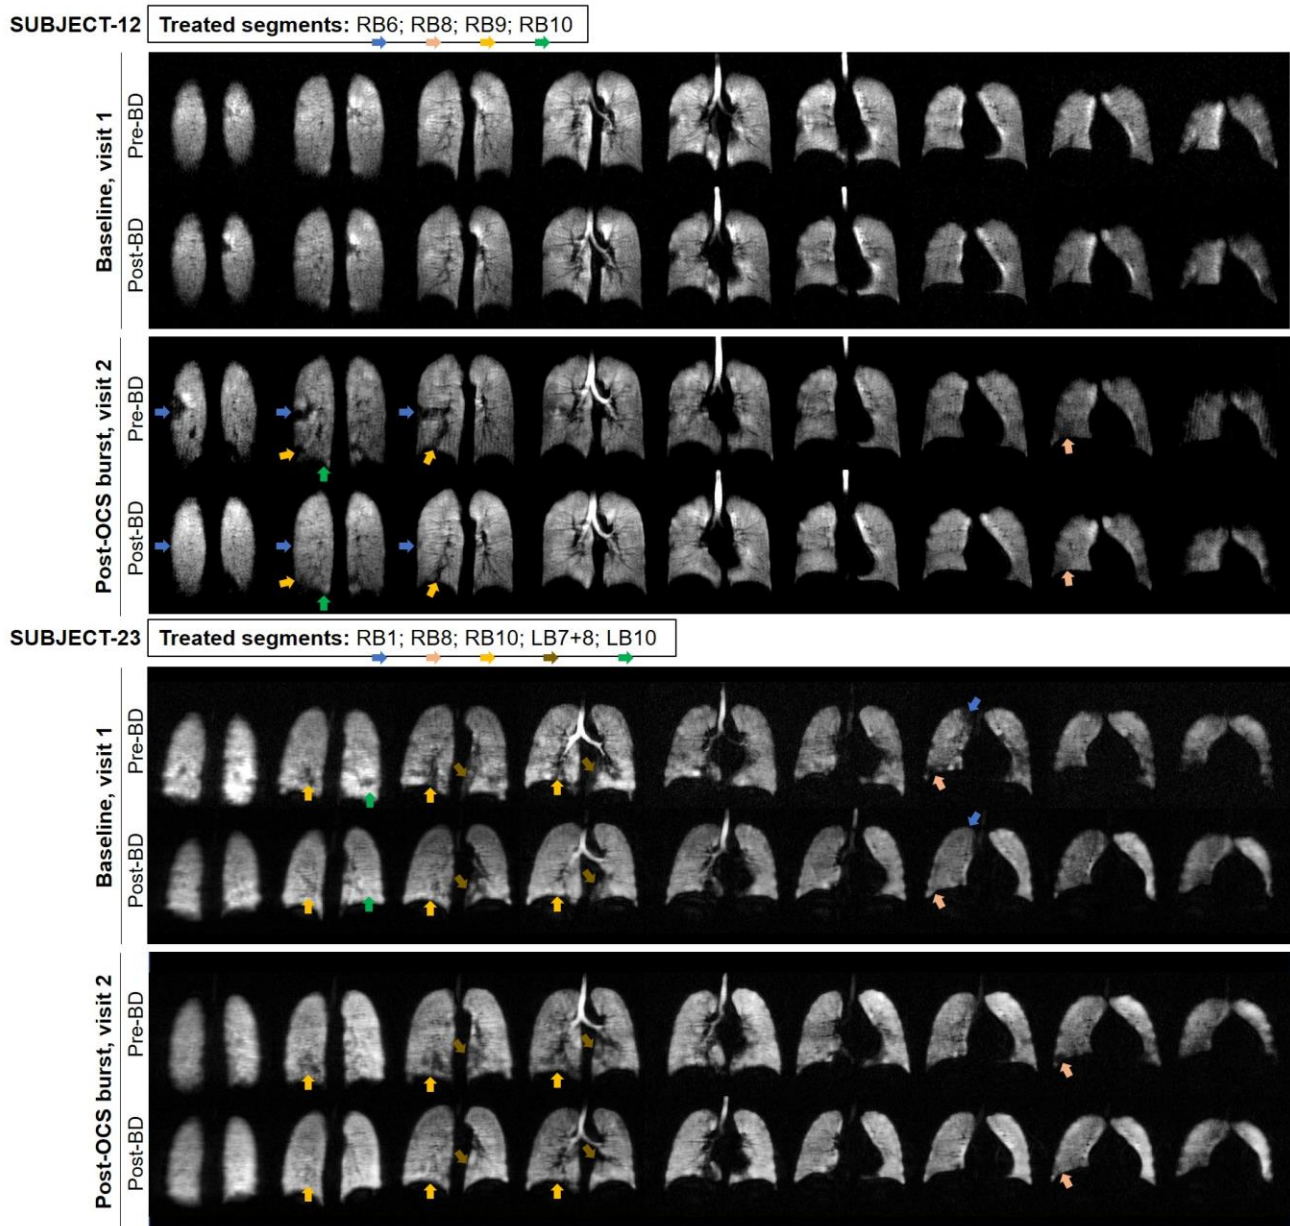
Representative examples of focal airway targets identified by inhaled hyperpolarized gas MRI.
